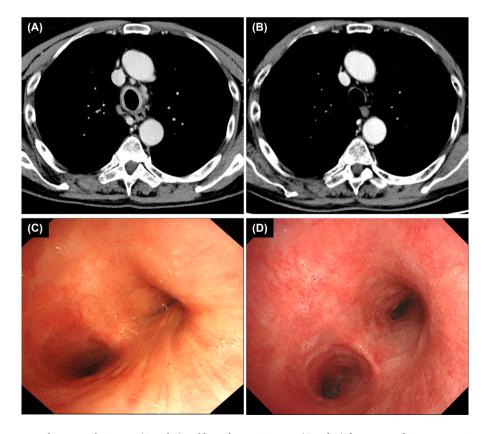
Chest computed tomography images (A and B) and bronchoscopic images (C and D) demonstrated improvement in tracheobronchial relapsing polychondritis after treatment with oral prednisolone. The images show findings before (A and C) and 1 month after (B and D) treatment.
